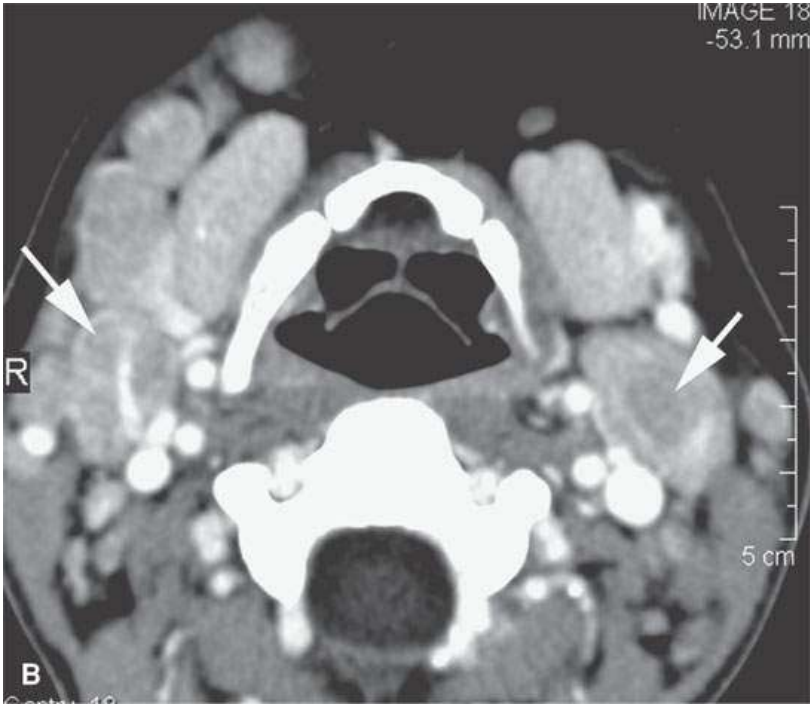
Contrast-enhanced computed tomography of unusual variable nodal morphology of lymphoma at the time of original presentation (in an HIV-positive patient) and prior to any treatment (A, and B) and nodal necrosis in a treated patient (C, and D). A: Eccentric defect in a node (*black arrows*), complete parenchymal replacement (*black arrowhead*), irregular replacement in a large node (*white arrowheads*), targetlike appearance due to peripheral node infiltration (*white arrow*). B: Partial parenchymal replacement by lymphoma in larger nodes (*arrows*). C, D: Areas of probable frank necrosis (*arrows*) and perinodal edema (*arrowheads*).
